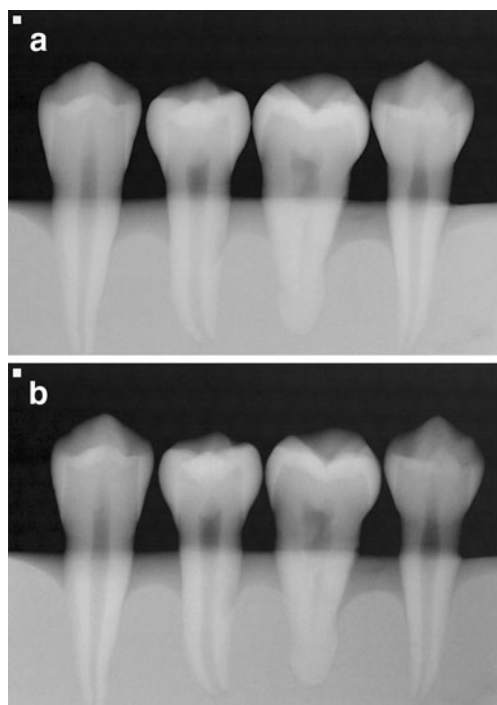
a Radiograph of teeth mounted in a block of PRESIDENT putty (Coltène Whaledent AG, Cuyahoga Falls, OH, USA) and exposed at 60 kV. b Radiograph of teeth mounted in a block of PRESIDENT putty (Coltène Whaledent AG, Cuyahoga Falls, OH, USA) and exposed at 70 kV
